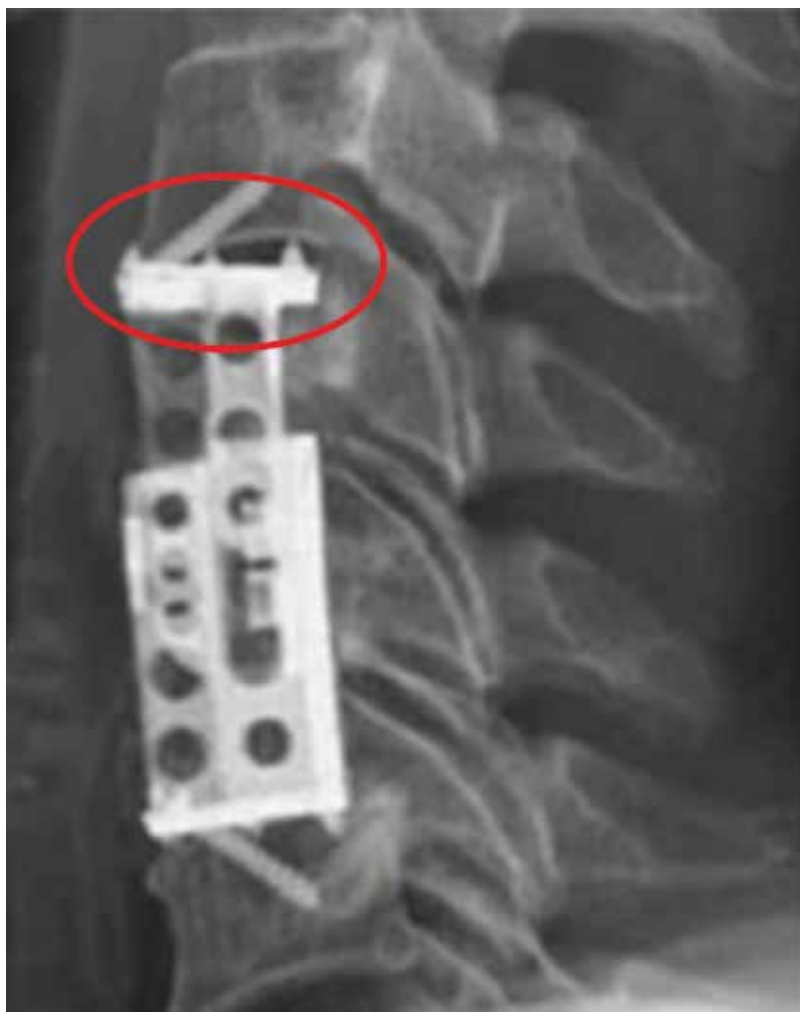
X-ray image of an implemented vertebral body replacement implant.
